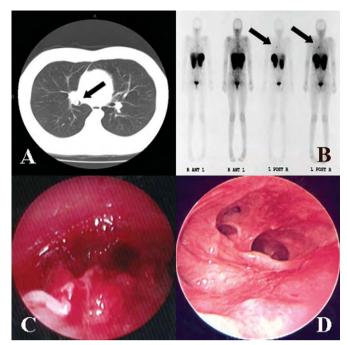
Radiographic assessments and surgical intervention in three cases of childhood bronchial carcinoid tumor. A, A 1.5-cm endobronchial lesion within the bronchus intermedius of an 18-year-old man as noted on computed tomography scan of the chest. B, Scintigraphy with a radiolabeled somatostatin analogue identified residual carcinoid tissue in the right lung of an 11-year-old girl, despite previous surgical removal. Rigid bronchoscopy demonstrated an obstructing polypoid mass (C) in the bronchus intermedius of a 7-year-old girl but a widely patent airway (D) following sleeve resection of the carcinoid tumor.
